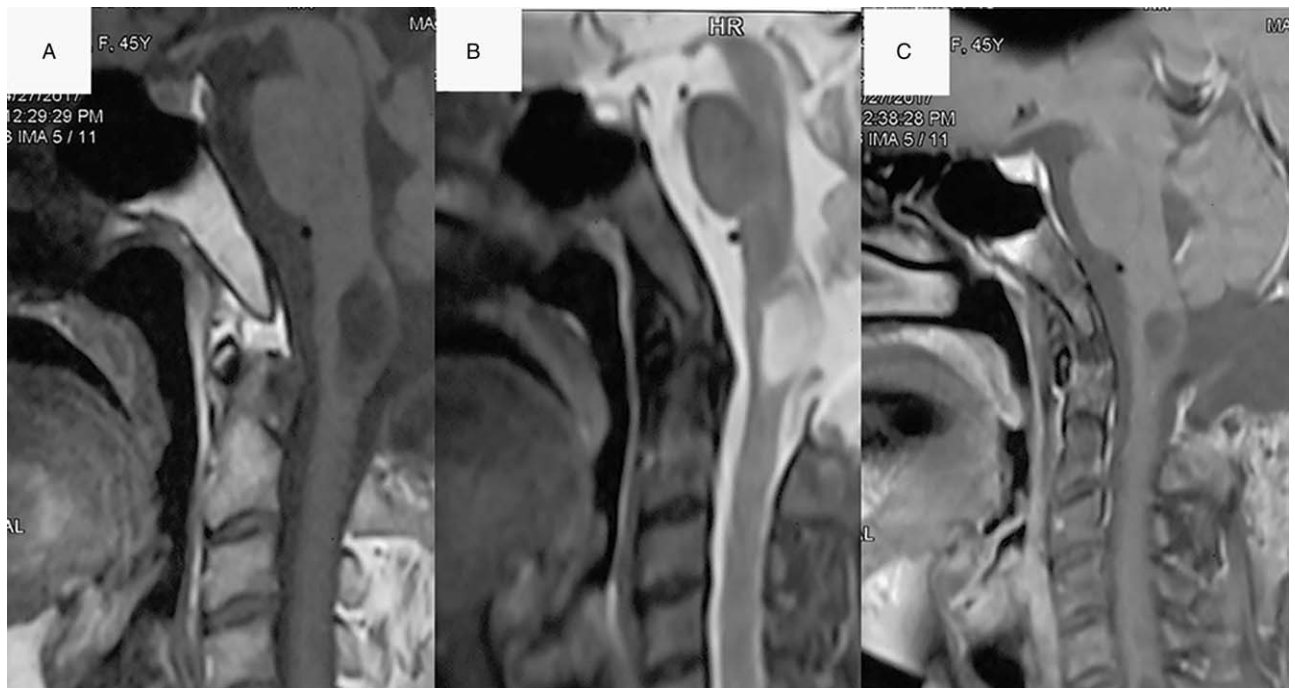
Magnetic resonance imaging (MRI) 3 months after operation. Sagittal magnetic resonance T1-weighted (A), T2-weighted (B), and contrasted T1-weighted imaging showed no recurrence and the syringomyelia disappeared.
